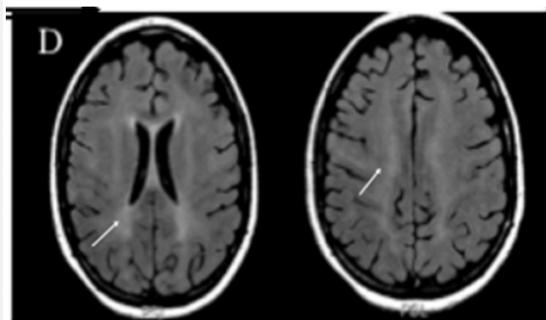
Repeat MRI on day 16 showing confluent subcortical hyperintensities.
